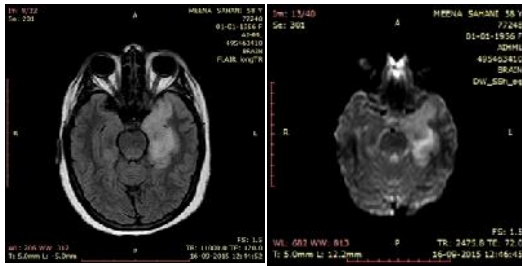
Axial FLAIR and DWI images showing areas of hyperintense signals in median temporal lobe including hippocampus and parahippocampal gyrus.
